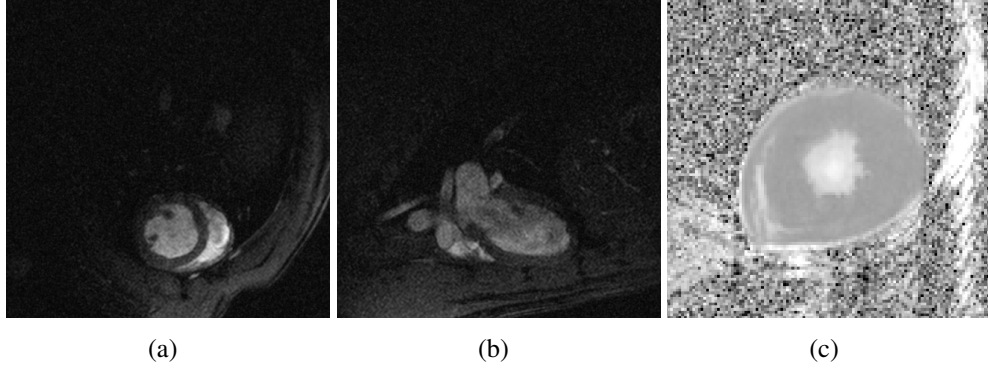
(a) Short-axis cine-MRI image at end-diastole from *dataset₂*. (b) 2-chamber long-axis cine-MRI image at end-diastole from *dataset₂*. (c) Midventricular short-axis slice of the *ADC* image from *dataset₂*.
